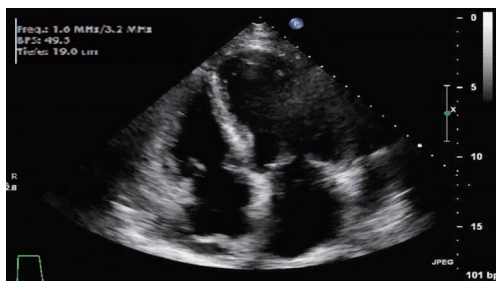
Apical 4-chamber view echocardiogram: normal values of the LV and the RV with normal systolic function of the LV and the RV without signs of right ventricular overload. Except for a mild mitral and pulmonary valve insufficiency there were no further hemodynamically relevant defects. Mild dilatation of the left atrium, indicating a grade I diastolic dysfunction. A small pericardial effusion was also detected. LV, left ventricle; RV, right ventricle.
